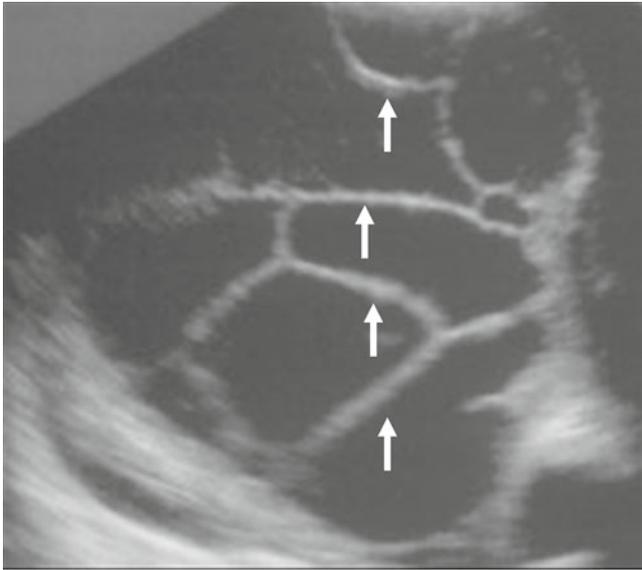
Pleural effusion. Ultrasound image shows a large pleural effusion with multiple septations (*arrows*) representing fibrin bands in a patient with empyema
